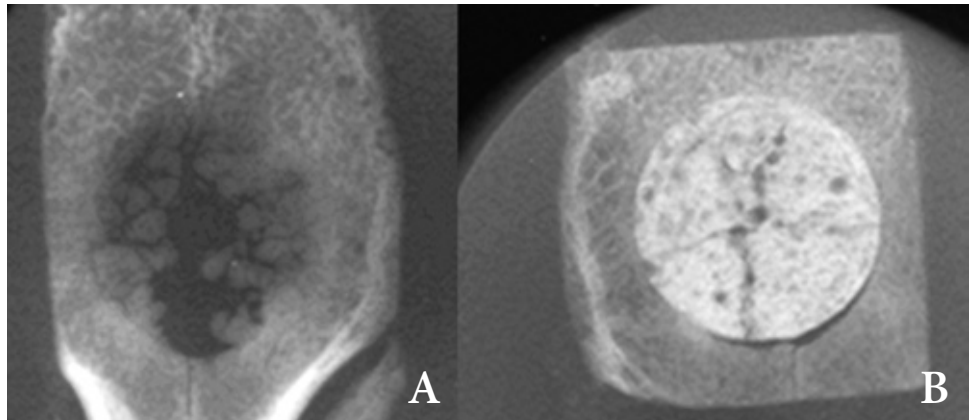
Radiographic analysis.*
